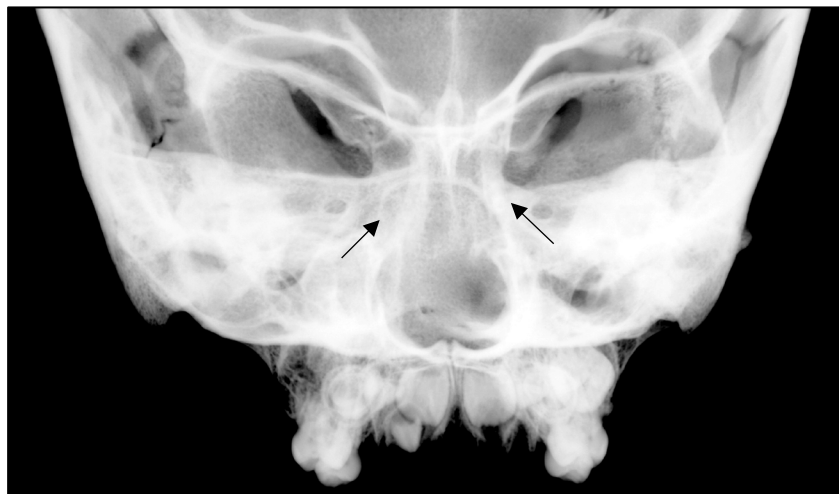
OL Grade 3 (Edo Period Japan, Cranium). This lesion was not observed macroscopically. Radiographs demonstrate a circular focal lesion with sclerotic margins of the nasal cavity. The original size of the nasal cavity could not be estimated, and bone loss occurred spherically therefore the maximum diameter of the nasal margin was used as a basis for lesion coding (over 5cm in diameter). Image: author's own.*
